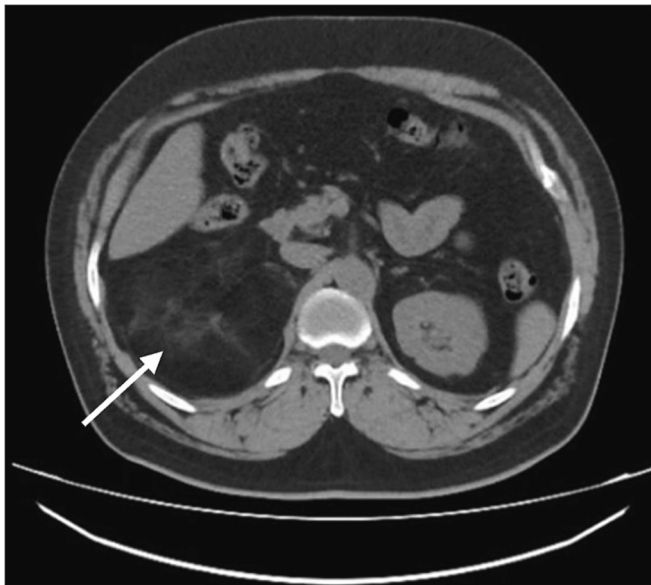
Enhanced computed tomographic showing the lesion. (arrow indicates the lesion).
